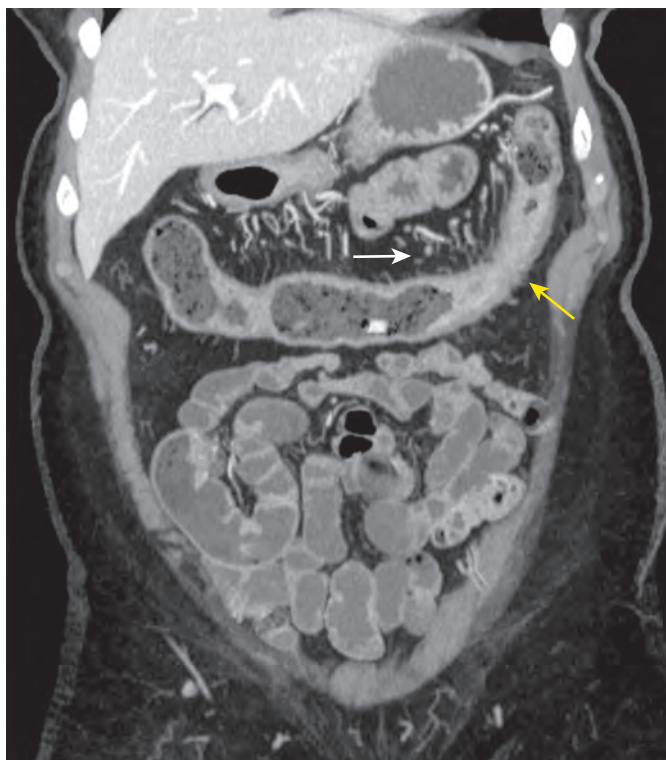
Coexisting acute and chronic Crohn's disease: CT findings. There is stenosis of the distal transverse colon (yellow arrow), indicating chronic disease. There is also some hyperenhancement of the mucosa of the more proximal transverse colon with engorgement of the vasa rectae (white arrow), indicating coexisting active disease.
